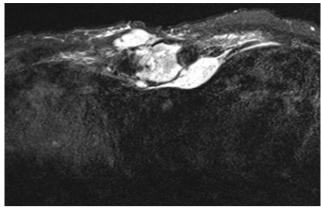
T2-weighted axial magnetic resonanse (MR) image showing a very high signal of the sternum.
